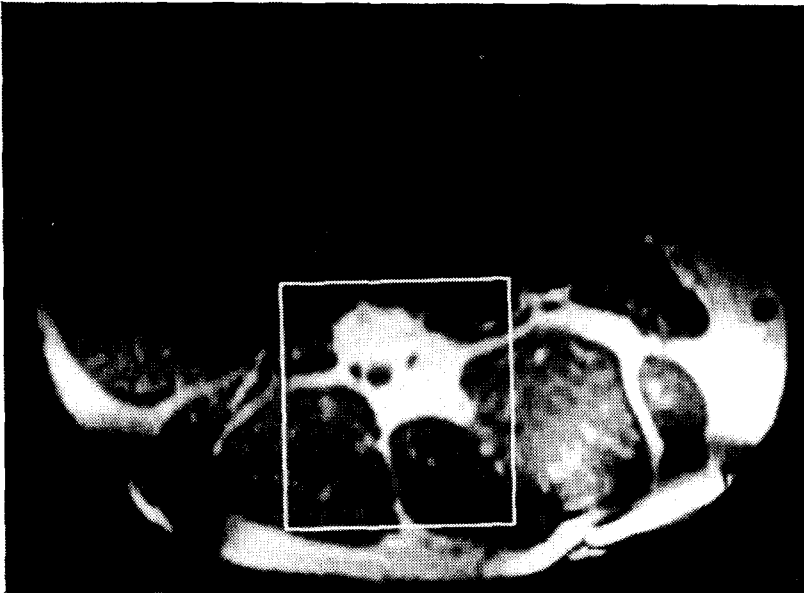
T1-weighted MR image obtained from the muscle tissue of the right thigh of a normal volunteer defining the VOI. The size of VOI located within the muscle is $5 \times 5 \times 5$ cm.
